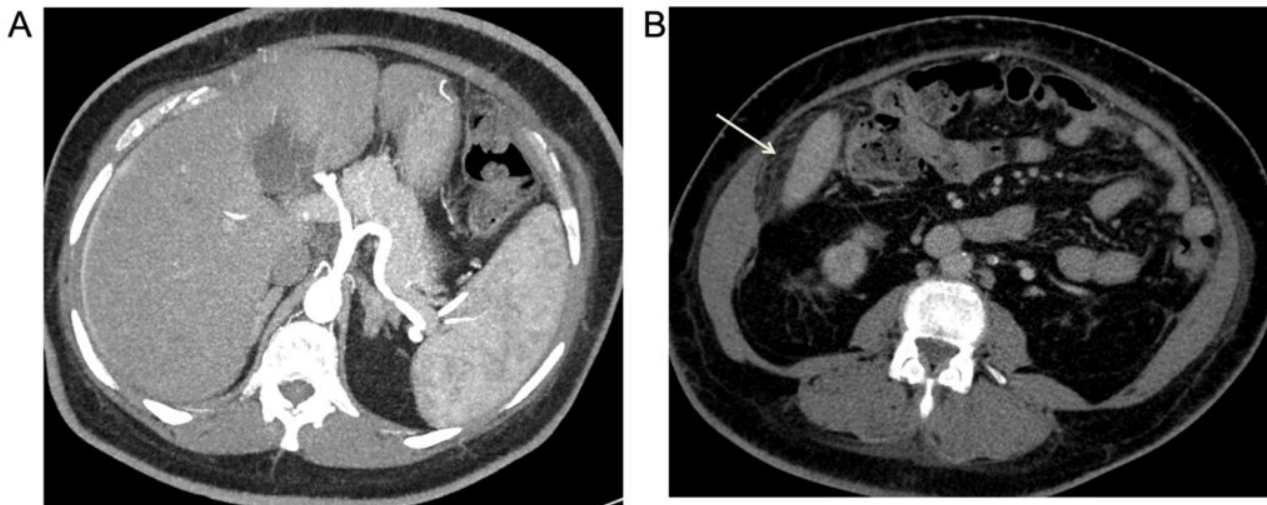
A. Arterial phase CT scan shows linear enhancement at lateral surface of right hepatic lobe. B. Portal phase CT scan shows perihepatic fat stranding (arrow).
